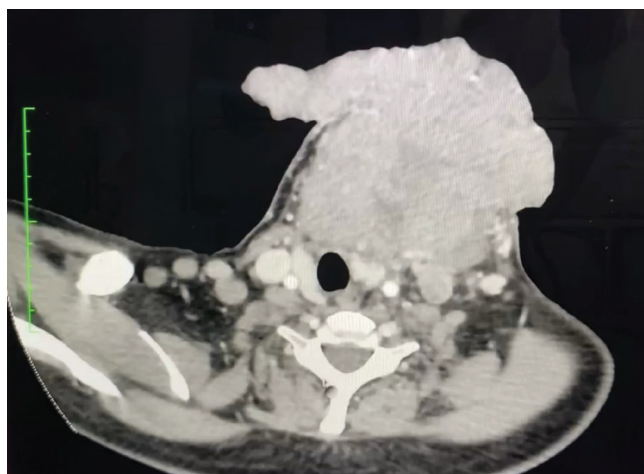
Neck CT with contrast coronal view at the C7-T1 showing a large, mixed attenuating, heterogeneously-enhancing fungating mass arising from the left thyroid lobe measuring 14.1 x 14.1 x 11.1 cm with areas of necrosis and hemorrhage. The mass causes a displacement of the trachea to the right side. Cut-off of the internal jugular vein on the left at the level of the C7-T1 and opacification of the left IJV is observed at the level of C7, representing thrombus formation.
